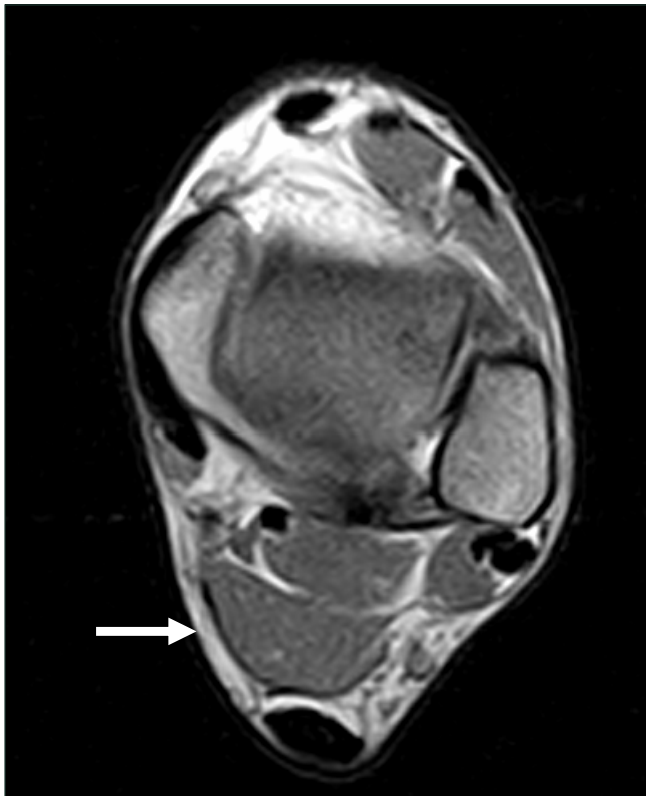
MRI of accessory soleus muscle belly (arrow) lying between the Achilles tendon and the flexor hallucis longus muscle belly.
